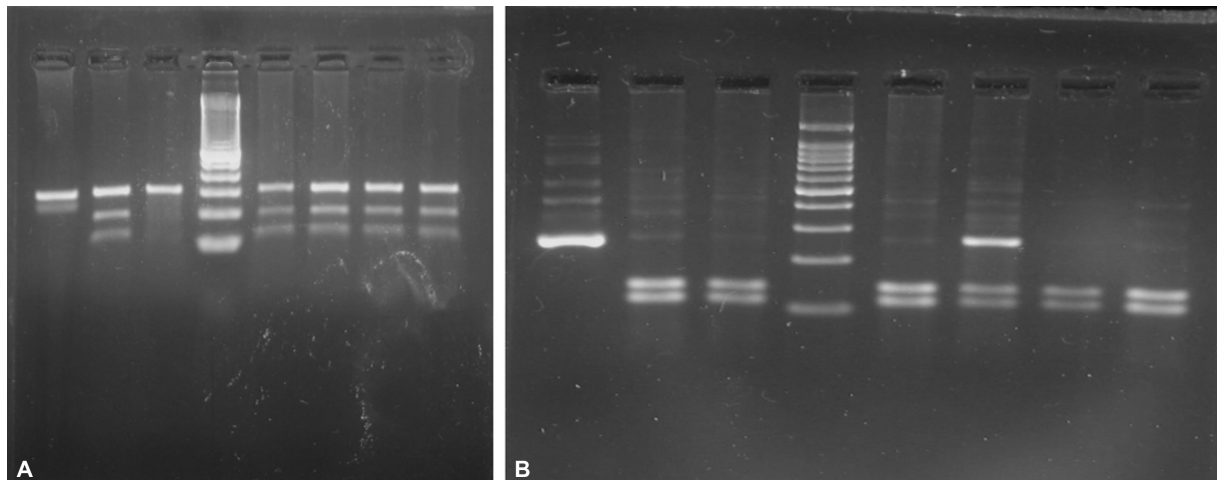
(A) Agarose gel picture showing interleukin (IL)-1 β (-511C/T) gene polymorphism: Lanes 1 and 3, TT genotype; Lanes 2 and 5–8, CT genotype; Lane 4, molecular marker 100 bp. (B) Agarose gel picture showing IL-1 β +3953 C/T gene polymorphism: Lane 1, TT genotype; Lanes 2, 3, 5, 7, and 8, CC genotype; Lane 6, CT genotype; and Lane 4, molecular marker 100 bp.
